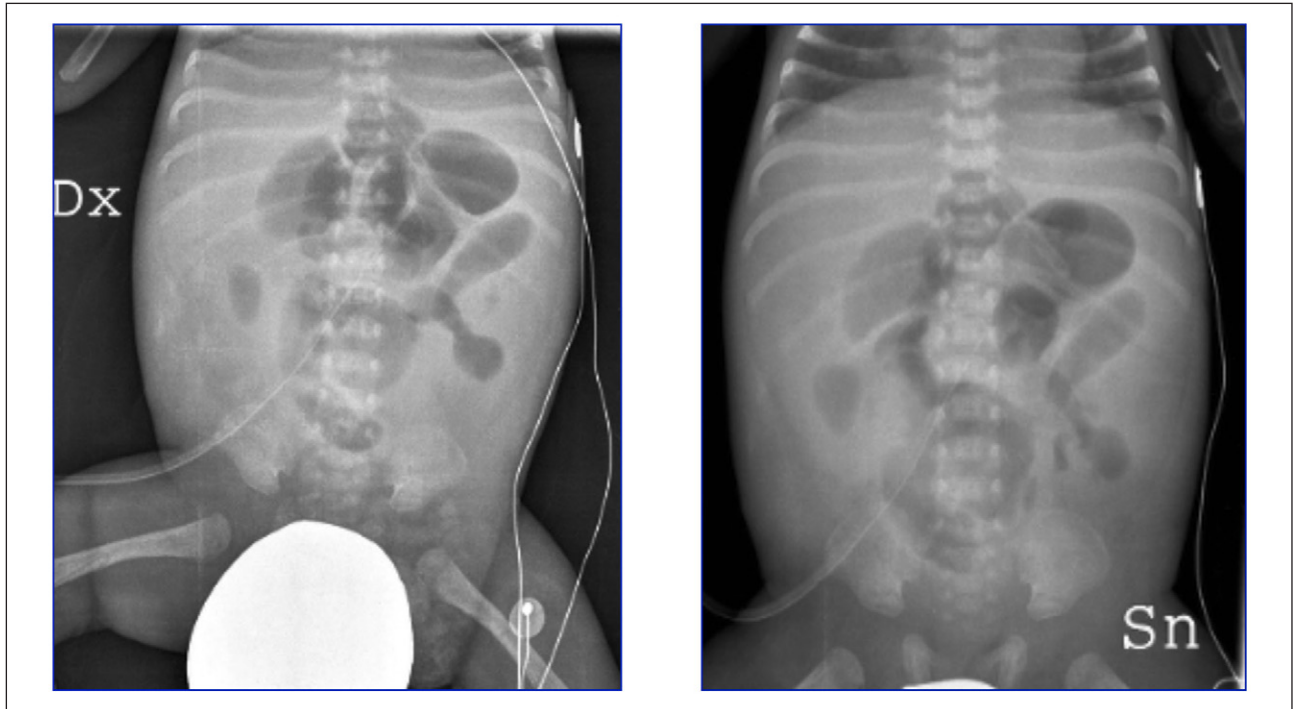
Supine (A) and lateral (B) radiographs of the abdomen obtained in a neonate with necrotizing enterocolitis (NEC) showing bowel wall thickening, dilatation of the loops with gas and extensive intramural gas.
